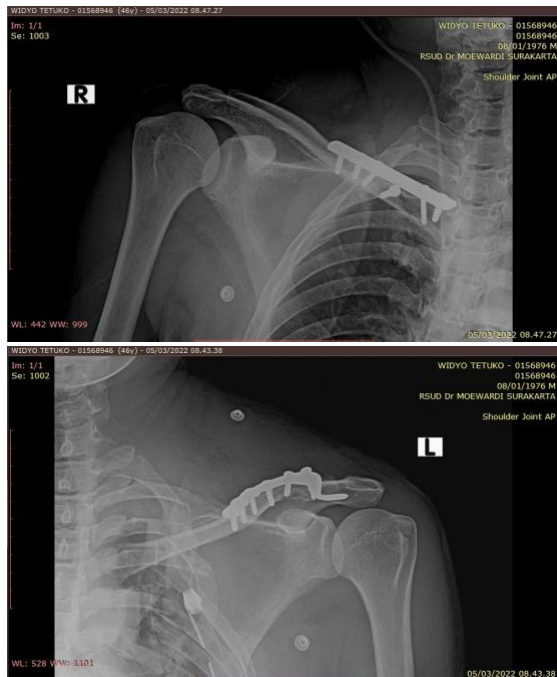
Postoperative anteroposterior radiographs of the bilateral shoulder joints. The middle third fracture of the right clavicle was fixed with hook plate and distal third fracture of the left clavicle was fixed with S-shaped locking plate.
